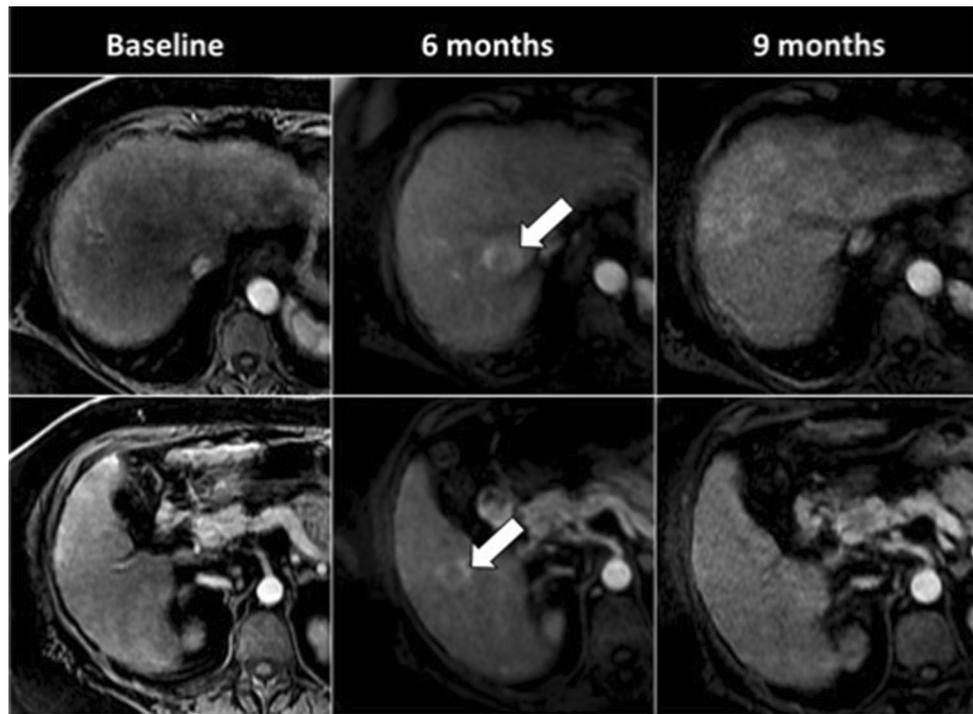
72-year-old woman with NASH cirrhosis. On baseline MRI examination, no focal liver lesion is noted on the images obtained during the hepatic arterial phase. At six-month follow-up MRI, two lesions (arrows) with rim arterial phase hyperenhancement in segments 8 and 6 are categorized as LR-M observations (i.e., high likelihood of being malignant but with imaging presentation not typical for HCC). These lesions disappeared on the follow-up MRI performed at 9 months with no interval treatment. Ultrasound target liver biopsy obtained after the six-month follow-up MRI showed active steatohepatitis without evidence of tumor
